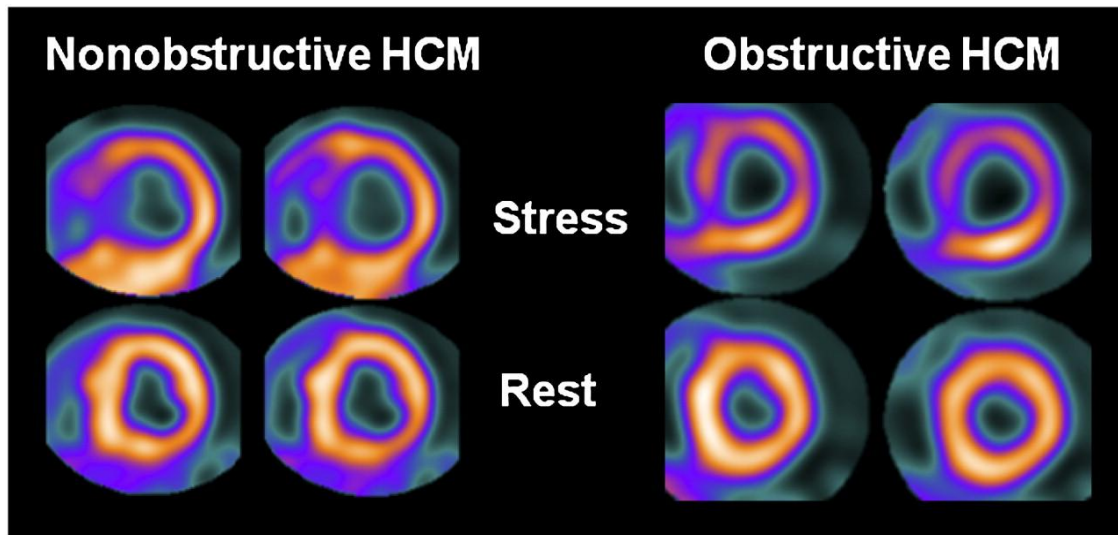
PET/CT Assessments for Obstructive and Non-Obstructive Hypertrophic Cardiomyopathy [22]
